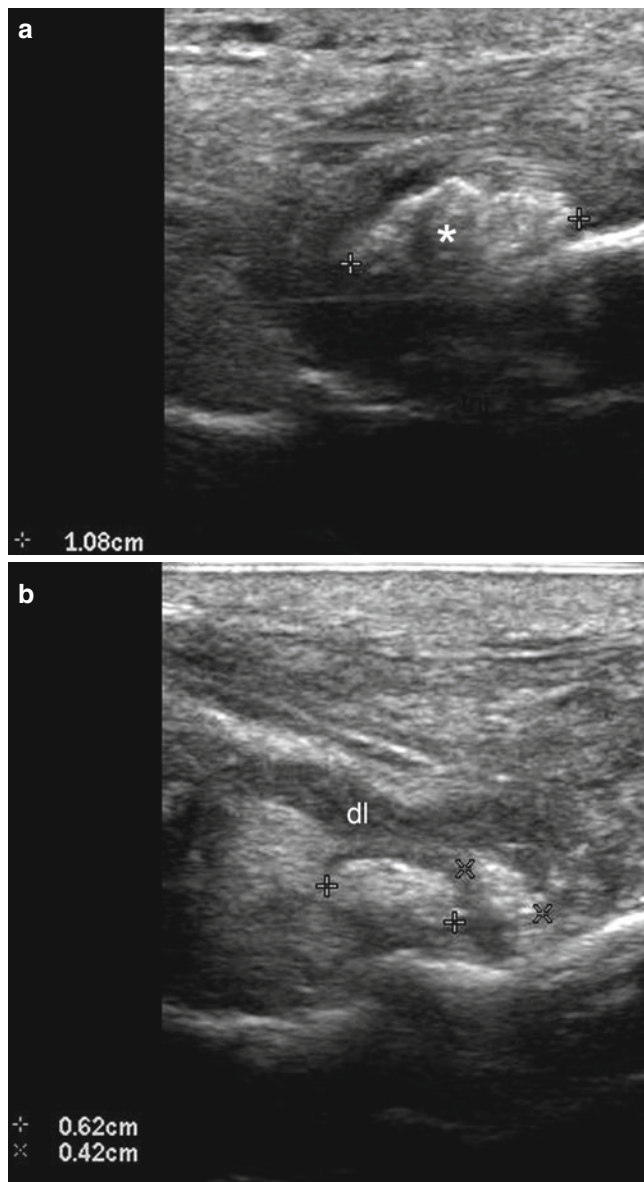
(a, b) Gouty tophi. (a, b) Grey scale ultrasound images (longitudinal views; left foot; a talonavicular joint region; b deltoid ligament area) demonstrate hyperechoic deposits that resemble “wet sugar clumps”. (a) 1.08 cm (long) deposit of crystals (*, between markers) is detected in the dorsum of the talonavicular joint. (b) Two deposits (between markers) that measure 0.62 cm and 0.42 cm (long), respectively, are well depicted in the medial aspect of the ankle close to deltoid ligament. *Abbreviations:* *tnj* talonavicular joint, *dl* deltoid ligament
